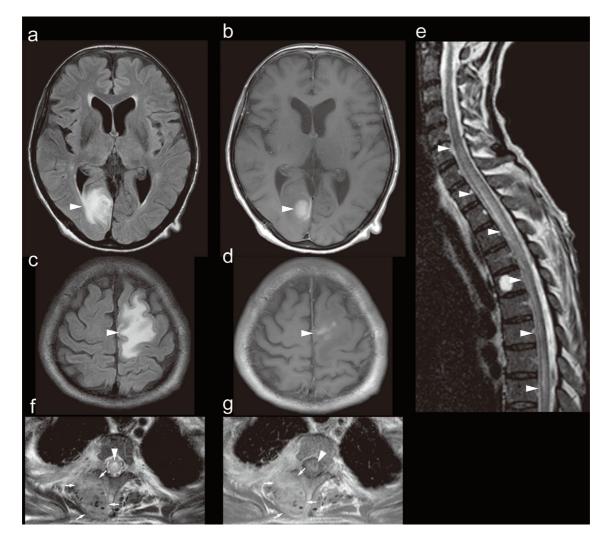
Magnetic resonance imaging findings of the patient. Brain magnetic resonance imaging (MRI) shows high-signal-intensity lesions in the right occipital lobe and left frontal lobe with partial gadolinium enhancement (a-d, arrowheads; a, c: fluid-attenuated inversion recovery; b, d: T1-weighted image with gadolinium administration). Spine MRI shows a longitudinally extensive spinal cord lesion in the C6-Th10 vertebral segments with partial gadolinium enhancement (e-g, arrowheads; e, f: T2-weighted image; g: T1-weighted image with gadolinium administration). Spine MRI also shows a poorly marginated, enhanced mass in the right paraspinal muscle (f, g, arrows).
